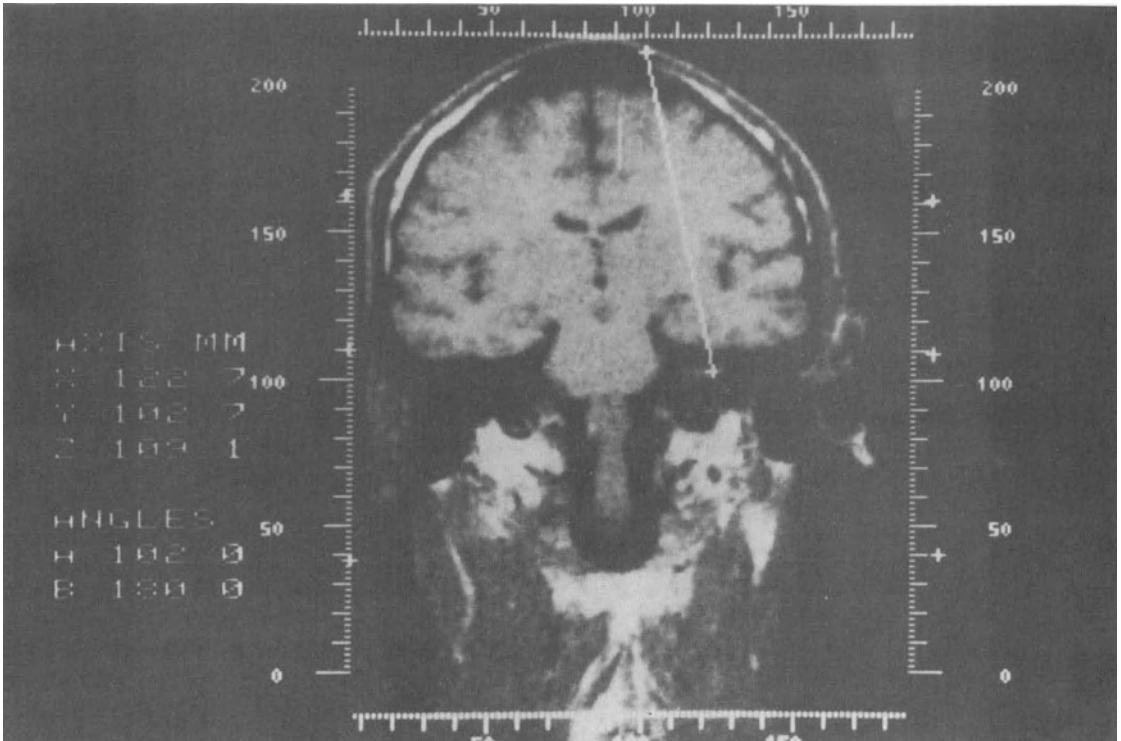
A coronal MRI (T_1 -weighted) scan demonstrating a small acoustic tumor.
